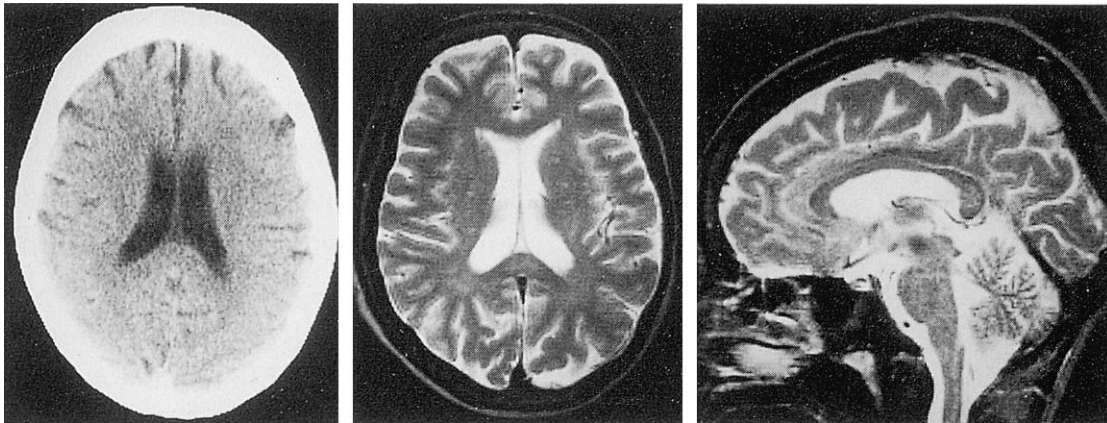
CT and MR images obtained 3 weeks after admission. CT disclosed no abnormality. Axial and sagittal T2-weighted MR images (SE 2500/90/1) demonstrated regression of both callosal hyperintensity and swelling, with only subtle hyperintensity of the splenium remaining.
